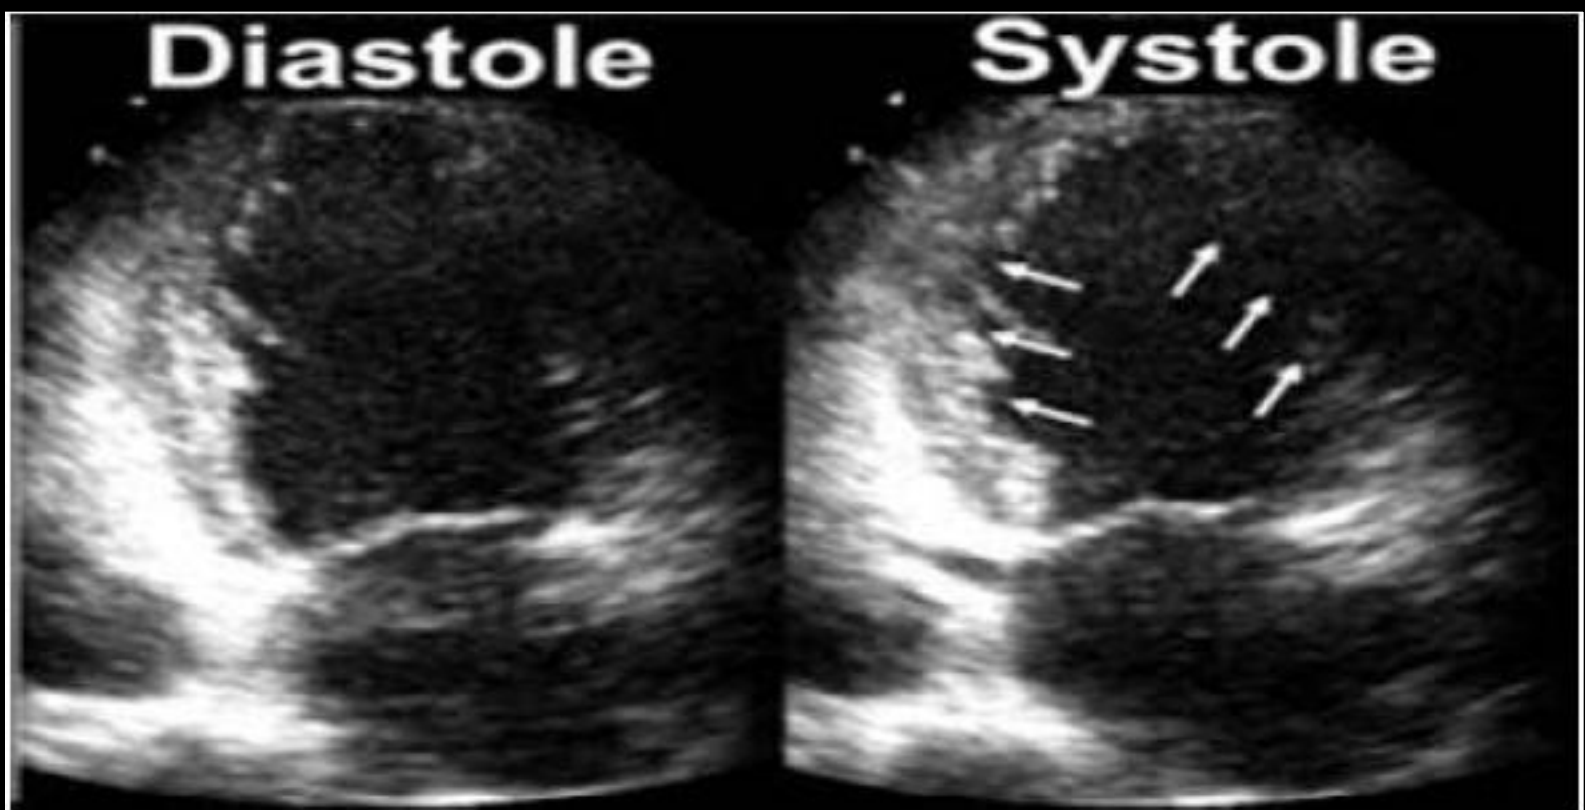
Echocardiogram of a patient with Hunt and Hess grade 3 subarachnoid haemorrhage showing midventricular wall motion abnormalities (arrows) in the apical two-chamber view. Wall motion score was 1.9 and ejection fraction 30%. (Modified from Tanabe *et al.*, 2008, with permission.)
